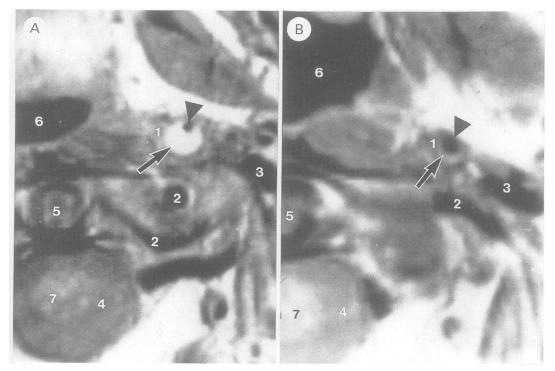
Follow up of ICA dissection by means of MRI imaging (T2-weighted, horizontal cut). (a) Initial examination showed hyperintense sickle-like vessel wall haematoma (arrow) leaving only small residual, hypointense lumen with blood flow (arrowhead). (b) Two weeks later, ICA lumen (arrowhead) nearly restored by resorption of intramural haematoma (arrow). 1 = internal carotid artery, 2 = vertebral artery, 3 = jugular vein, 4 = spinal fluid, 5 = dens axis, 6 = pharynz, 7 = medulla.
